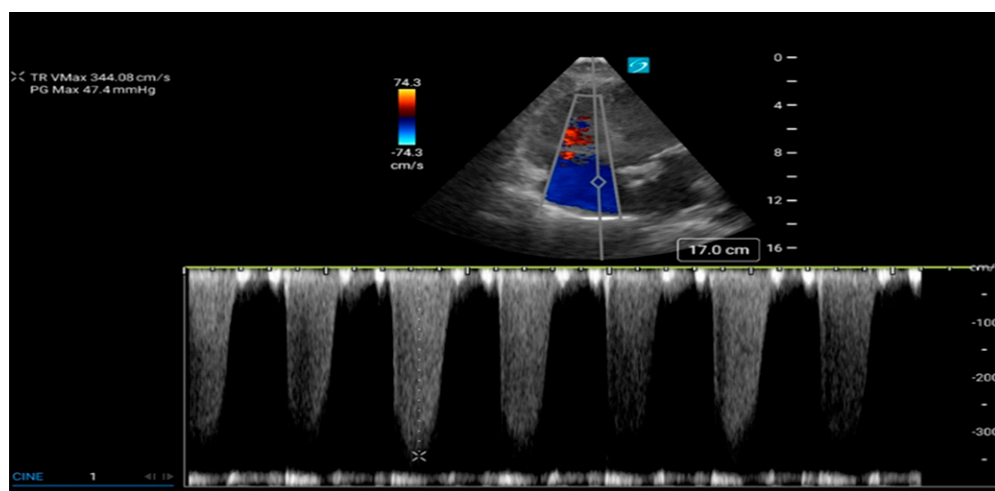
E-learning module 5 continuous-wave Doppler estimation of TR jet velocity. PG = pressure gradient; TR = tricuspid regurgitation.
